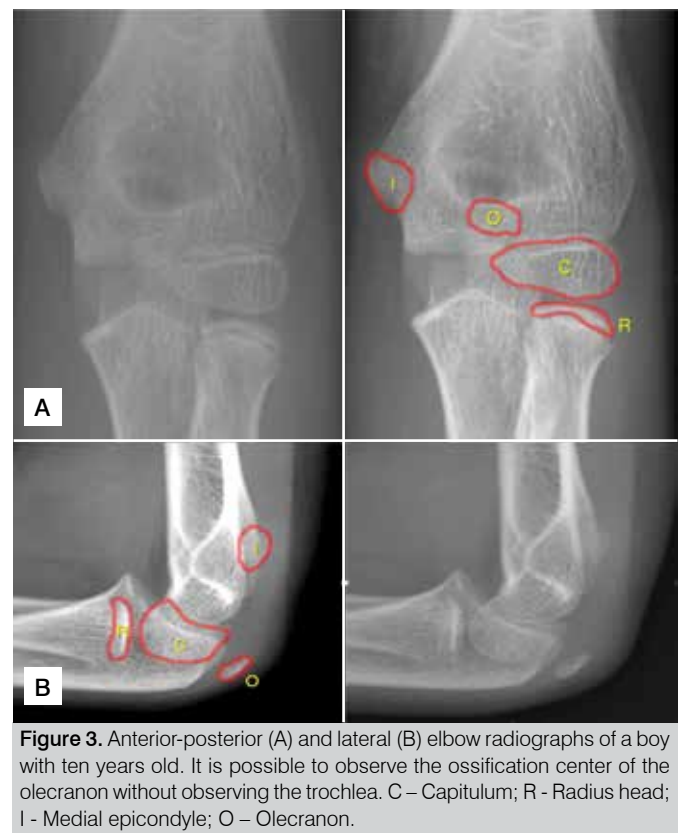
Anterior-posterior (A) and lateral (B) elbow radiographs of a boy with ten years old. It is possible to observe the ossification center of the olecranon without observing the trochlea. C – Capitulum; R - Radius head; I - Medial epicondyle; O – Olecranon.
